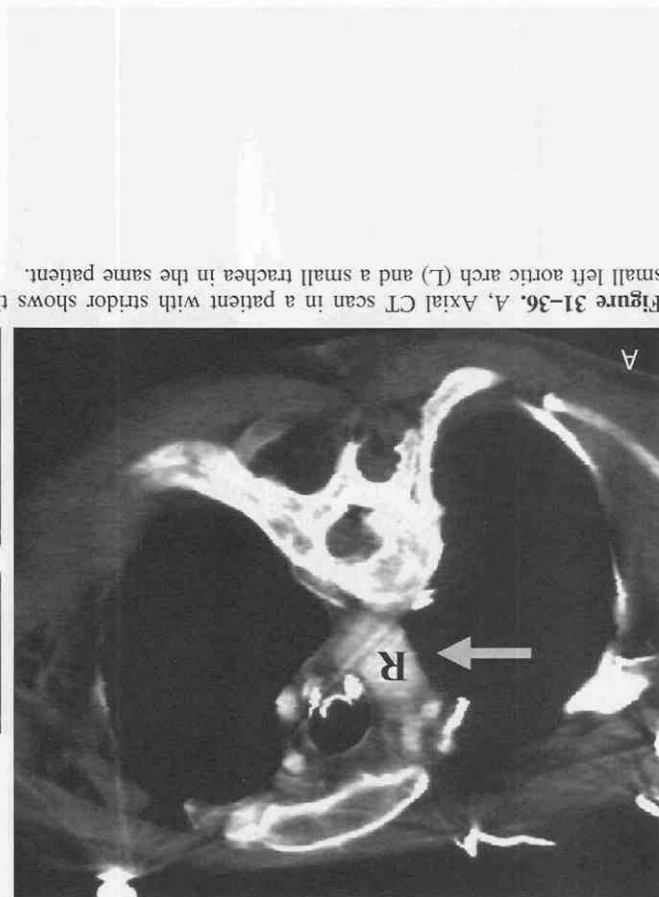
A, Axial CT scan in a patient with stridor shows the right aortic arch (R) and a small left aortic arch (L) and a small trachea in the same patient.
